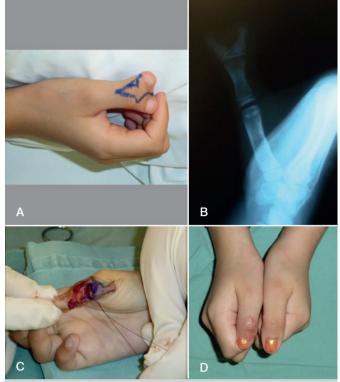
Clinical photograph of Bilhaut-Cloquet procedure. (A) Clinical aspect and preoperative planning of modified Bilhaut-Cloquet procedure. (B) Preoperative radiographic image. (C) Intra-operative image. (D) Late clinical result.
